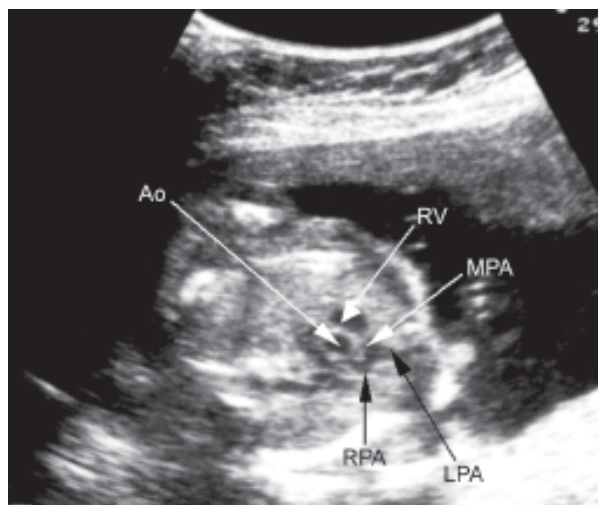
Parasternal short axis view of the right ventricle outflow tract (18th week)
